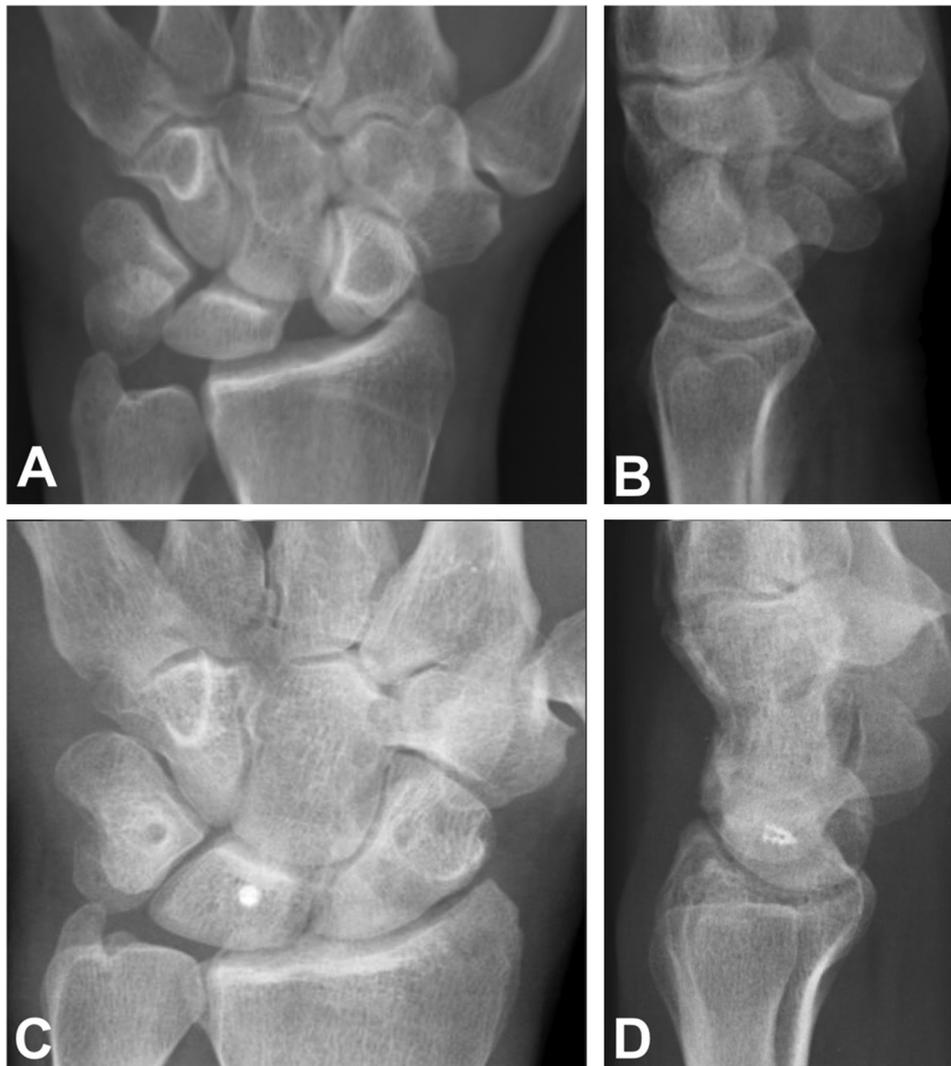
Example of scapholunate dissociation detected on anteroposterior (A) and lateral (B) radiographs. Postoperative anteroposterior (C) and lateral (D) radiographs at 40 months' follow-up after the SLICL procedure.
